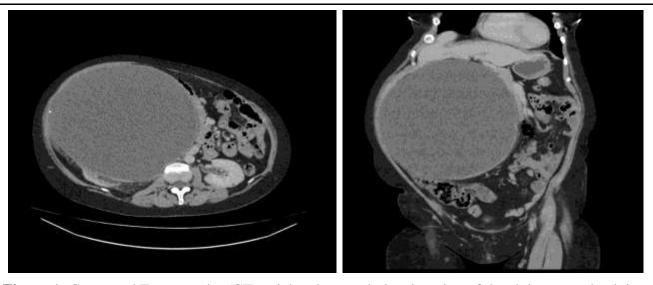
Computed Tomography (CT) axial and coronal view imaging of the abdomen and pelvis showing a giant renal cyst measuring 220 X 229 X 234mm on the right kidney.
